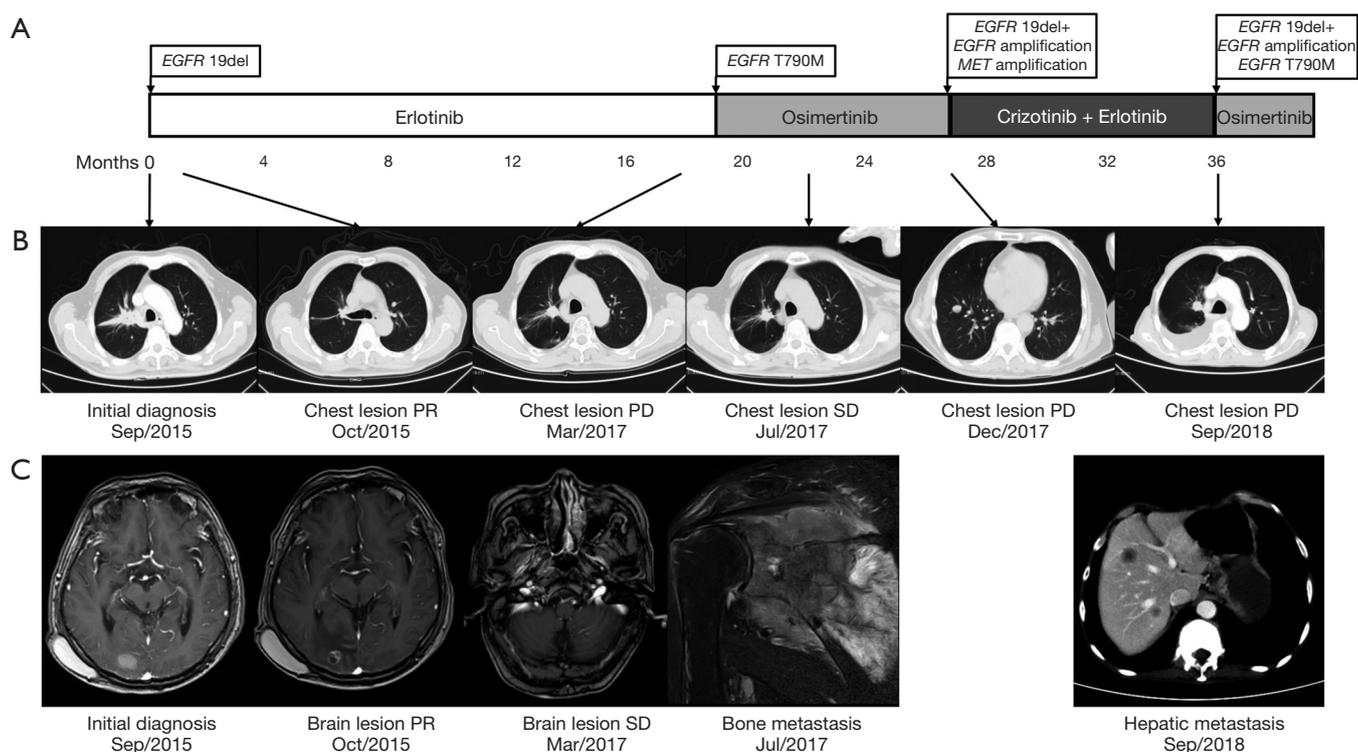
Timeline of patient's therapy and effect of therapy. (A) Genomic testing and targeted treatments; (B) chest CT scanning of primary lung tumor; (C) MRI of brain and bone metastasis; abdominal CT scanning of hepatic metastasis. EGFR, epidermal growth factor receptor; PR, partial remission; PD, progressive disease; SD, stable disease; CT, computed tomography; MRI, magnetic resonance imaging.
